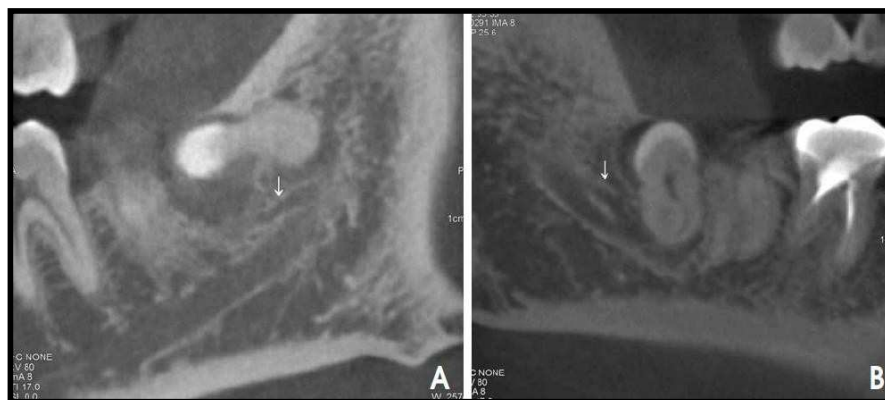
CBCT images show canal type 3 (forward canal type A without confluence, B with confluence)
